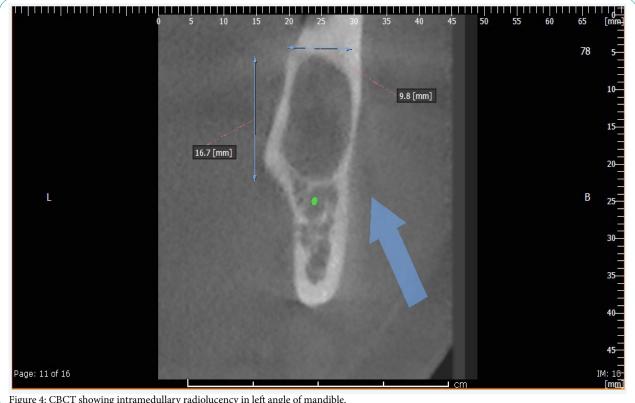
CBCT showing intramedullary radiolucency in left angle of mandible.
